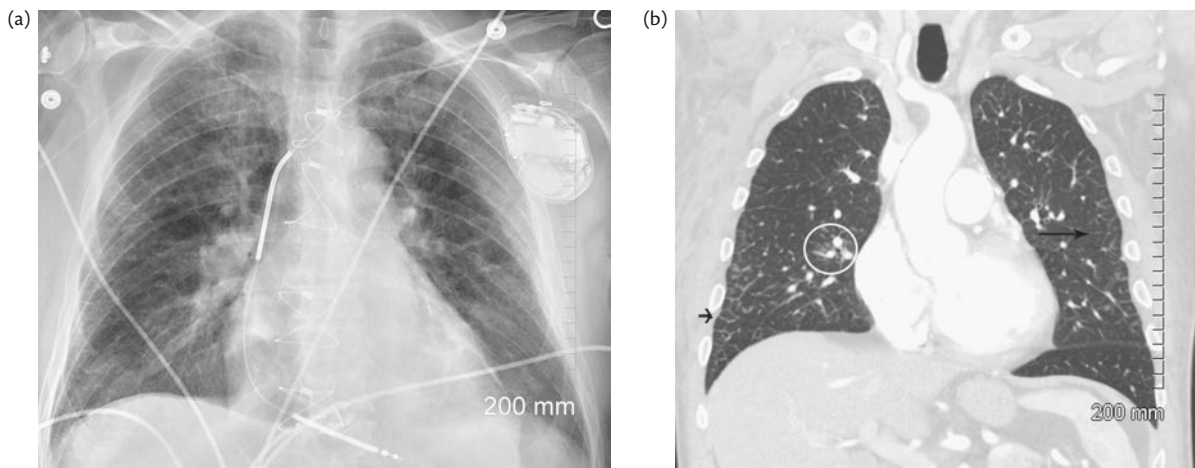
Case 3. (a) X-ray; (b) CT scan.
